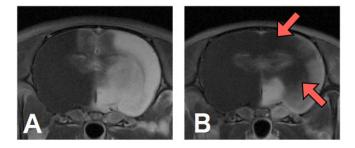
AIM MRI reflecting the BBB condition after $MnCl_2$ and glutamate injection. (A) BBB was disrupted homogeneously. (B) BBB of parietal cortex and a part of caudate-putamen were not disrupted in this case.
